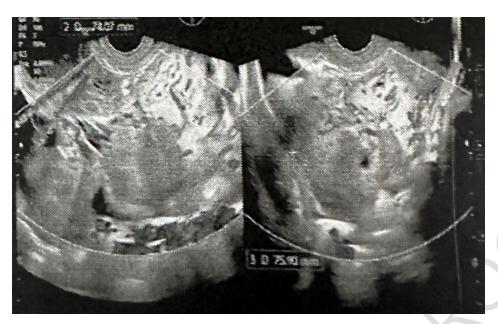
The ultrasound image of the left ovary depicts a solid hypoechoic mass measuring  $128 \times 74 \times 75$  mm. It lacks septations or nodularity and displays irregular outer margins. No evidence of posterior acoustic enhancement is observed.
